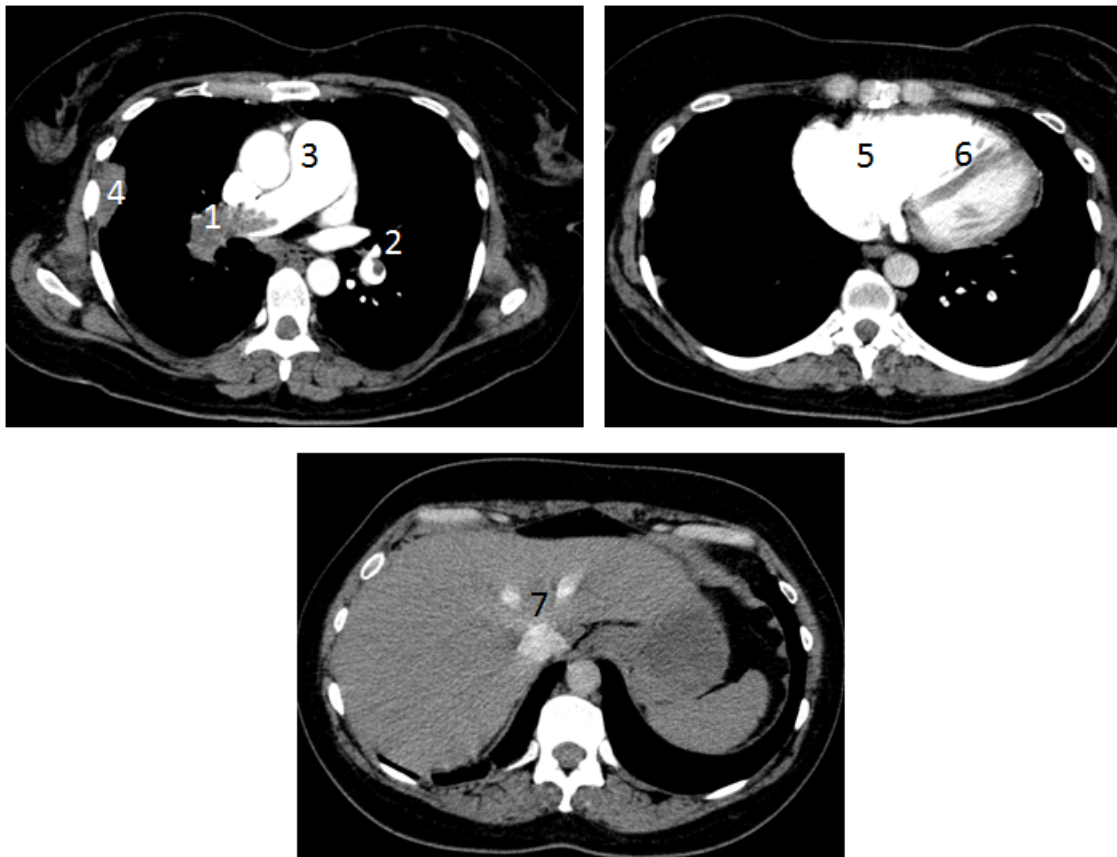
Computed tomography pulmonary angiography (CTPA) of the patient on admission
